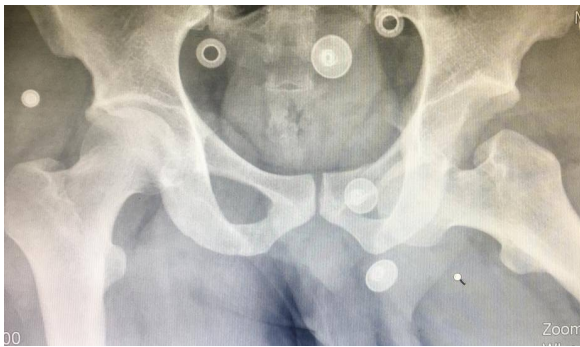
Anteroposterior radiograph of the pelvis showing an obturator dislocation of the left hip
